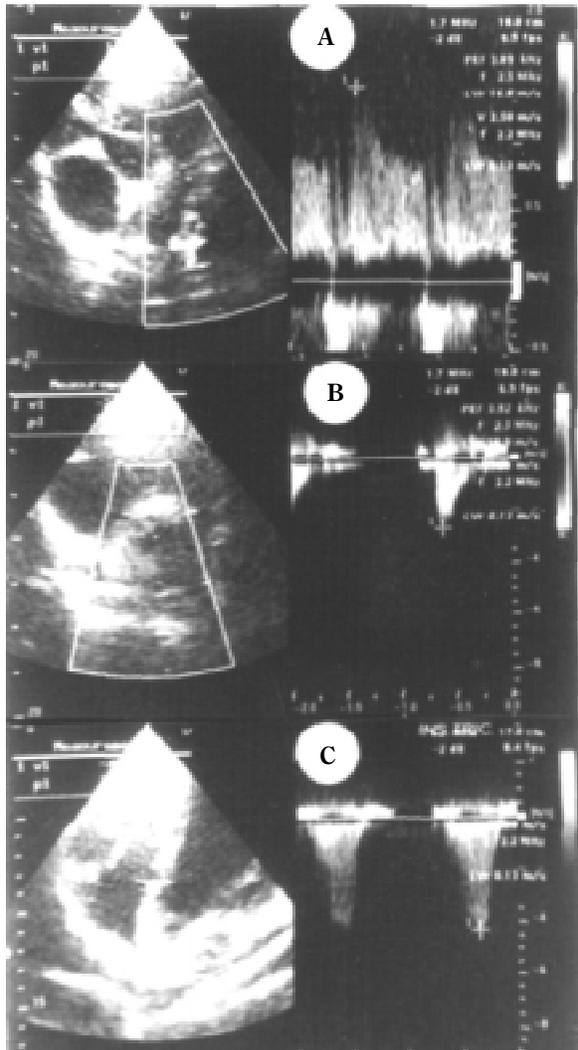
Doppler echocardiograms before surgical treatment. A. Parasternal short axis view. B. Modified parasternal short axis view, and C. Apical four chambers view. 1= Right atrium; 2 = right ventricular outflow chamber; 3= pulmonary artery; 4= left pulmonary artery (In A, continuous Doppler shows the blood flow jet emerging from the *ductus arteriosus*); 5= left atrium; 6= left atrium and ventricle; 7= Aorta, and right pulmonary artery.
